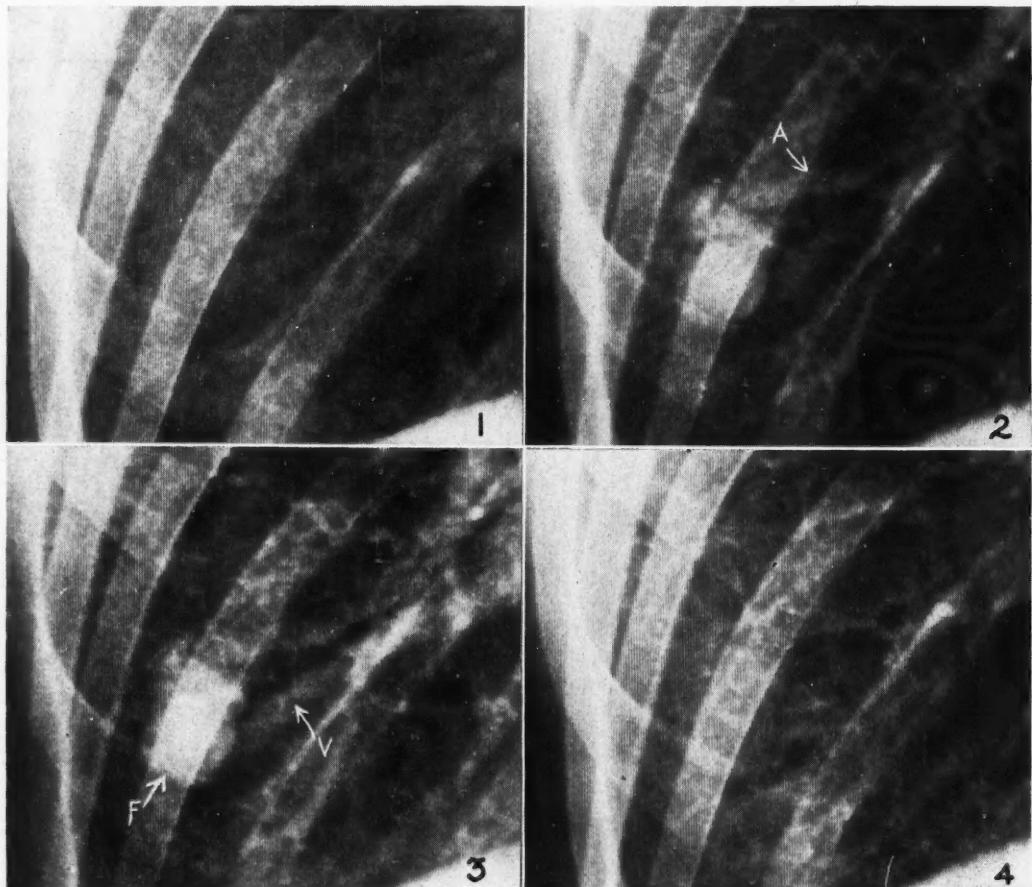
Four serial radiographs of a small density in right lower lung (taken at 1/2 second intervals) after injection of 70 per cent Diodrast into the cubital vein. The mass is seen to be an arteriovenous fistula (F) of the lung with demonstration in No. 2 of the opacified artery (A) and subsequently in No. 3 of the vein (V). The need for rapid film changing technique is well demonstrated in this series, as it can be seen that the pathology was only demonstrated for a possible maximum period of 1½ seconds.
